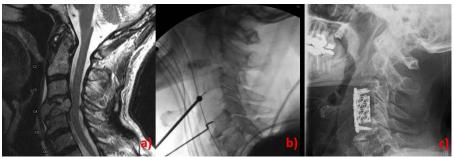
A 54 yo female presents with progressively worsening neck pain over several weeks. Sagittal T2 weighted MRI sequence demonstrates an
